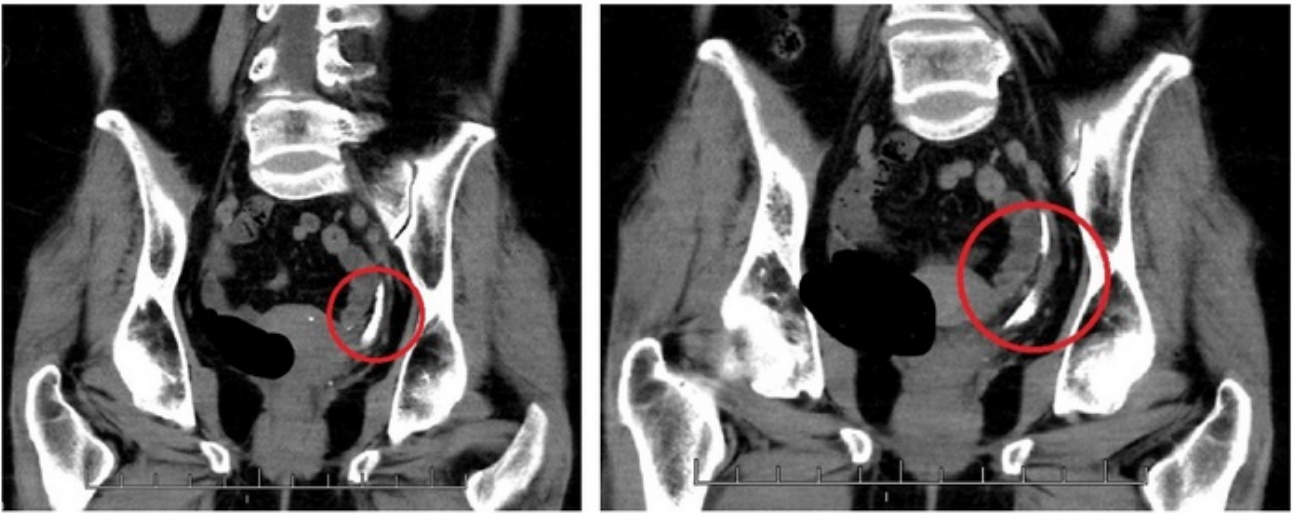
Preoperative CT abdomen pelvis scan showing kidney stone fragments in left distal ureter alongside ureteral stent
